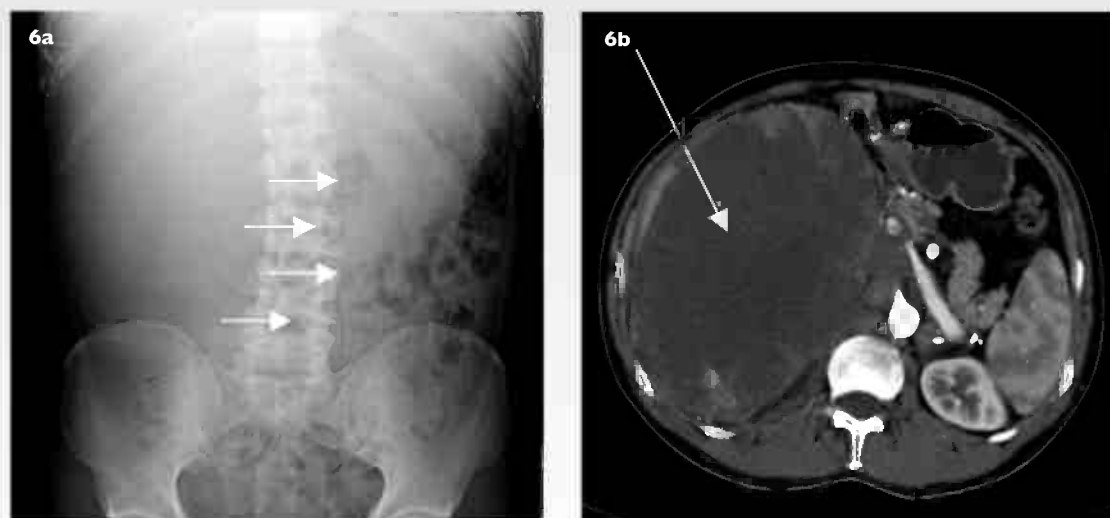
(a) Frontal abdominal radiograph shows a large right-sided RCC displacing bowel, as seen by the displacement of bowel shadows (arrows). (b) Corresponding axial CT image shows a very large right-sided RCC (arrow).
